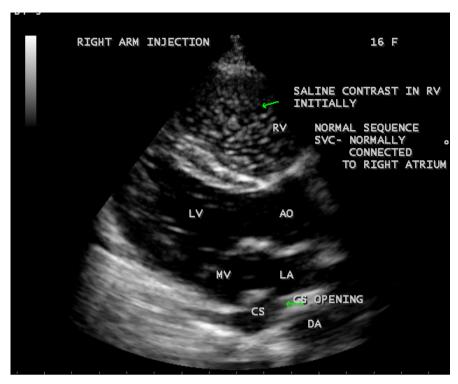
Bubble study showing the normal connection of right superior vena cava (RSVC) by early appearance of saline contrast in the right ventricle (RV)-right arm injection (Parasternal long axis view). (Note: If saline contrast appears earlier in CS than in the right-sided cardiac chambers (RA, RV), RSVC (right superior vena cava) is absent, PLSVC to CS is possible and the CS is aneurysmally dilated (giant CS).
